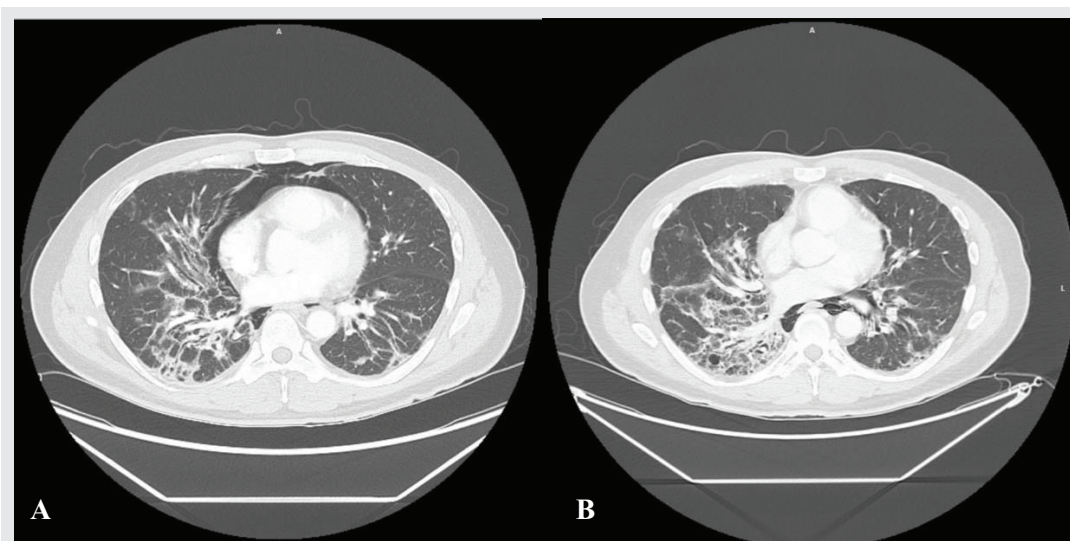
(A) Chest CT shows a large pneumomediastinum with large patchy opacification in the right hilar and posterior lower lobes bilaterally with general fibrotic changes to both lungs. (B) Chest CT at 12 weeks follow-up visit shows less extensive pneumomediastinum.
